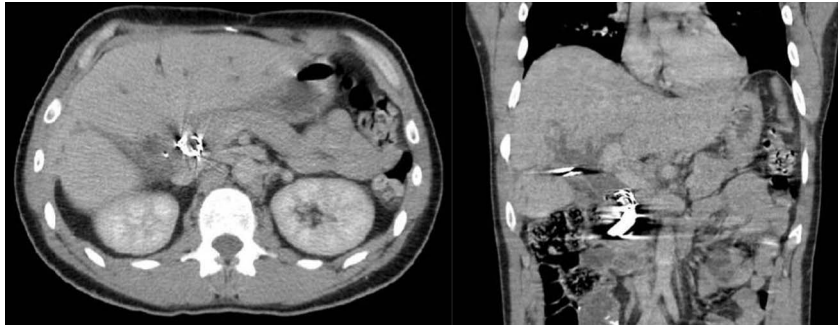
Computed tomography showing a mass at the hepatic confluence near the pancreatic head, raising concern for biliary obstruction by foreign body or coils.
